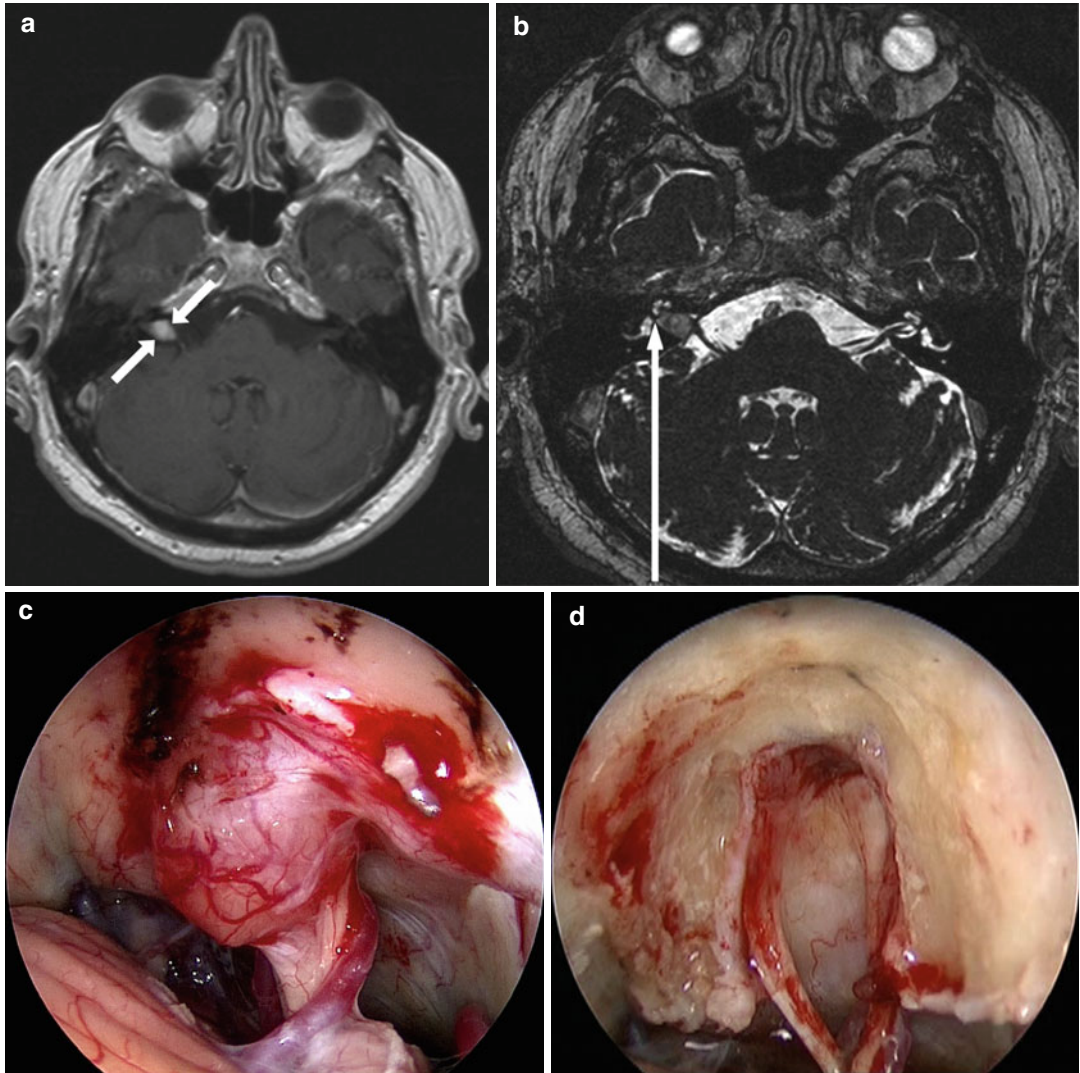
Intra-extrameatal vestibular schwannoma in a 58-year-old male presenting with hearing loss. (a) T1-weighted axial MR image showing a contrast-enhancing lesion (*arrows*) within the cerebellopontine angle. (b) Axial CISS MR image showing the accurate extension of the lesion with the internal auditory canal (*arrow*). (c) Endoscopic image of the tumor. (d) Endoscopic inspection of the internal auditory canal after tumor removal showing preserved facial and cochlear nerve. (e) Endoscopic
